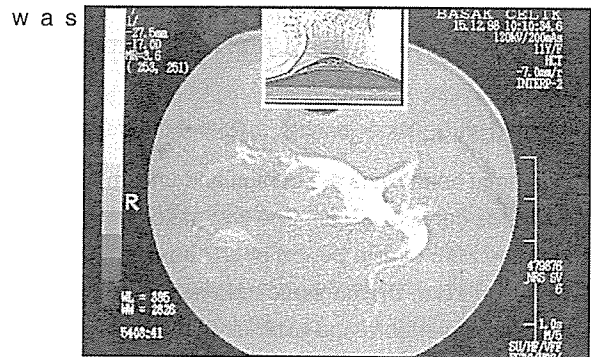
Cervical CT and 3D-CT scans showing the destruction of the sixth cervical vertebra
